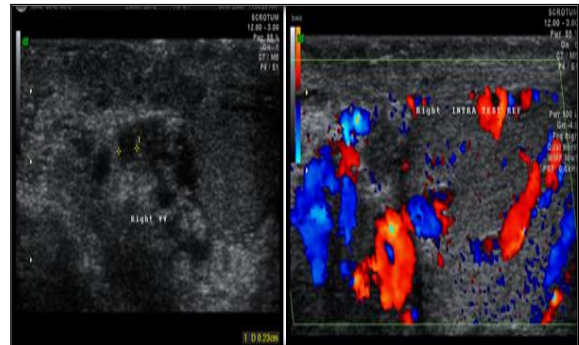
Infertile male patient of age 32 years with bilateral varicocele, showing dilated venous plexus (0.23) cm with intratesticular doppler reflux - Grade III on right side
